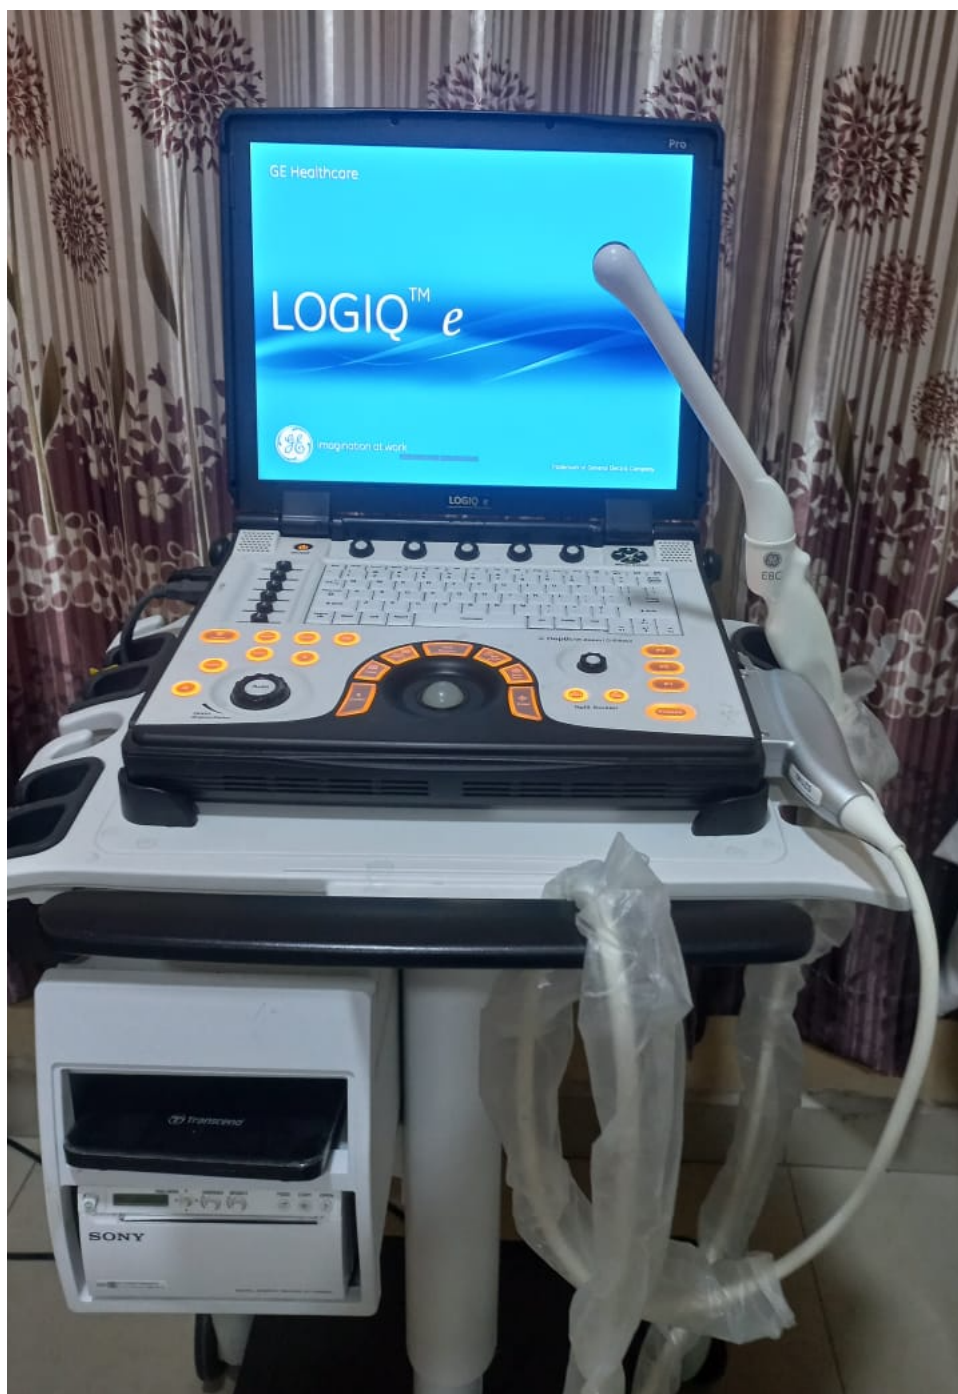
Image of the GE-LOGIC 5 ultrasound machine used for the study with the transvaginal probe
